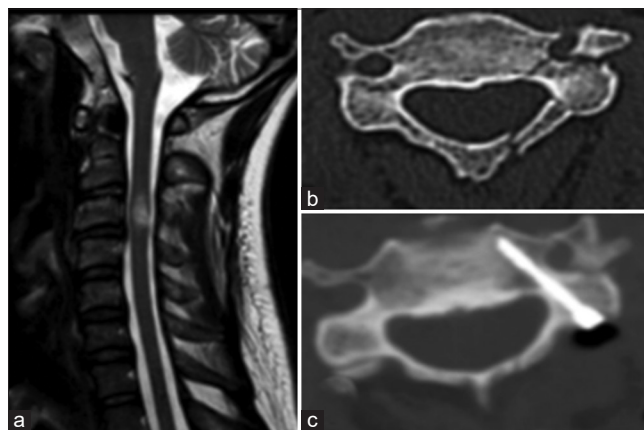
Male, 47-year-old. Fall from height. AO Spine C3: A0; F3; N3; M1 Frankel C. MRI showing medullary signal changes without apparent compression; without subluxation (a), Axial CT scan showing a floating lateral mass on the left in C3 (b), We opted for osteosynthesis of the lateral mass using the transpedicular technique with a 2.7 mm cannulated screw (c). MRI: Magnetic resonance imaging, CT: Computed tomography
